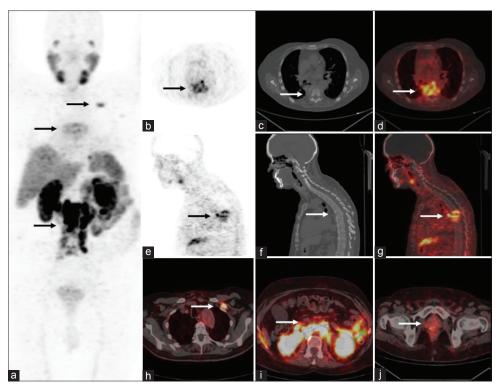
Multiple image projection (a) of whole-body Ga-68 prostate-specific membrane antigen positron-emission tomography/computed tomography scan showing multiple prostate-specific membrane antigen-avid metastatic lesions. Axial and sagittal positron-emission tomography, computed tomography, and fused positron-emission tomography/computed tomography (b-g) showing prostate-specific membrane antigen-avid destructive lesion of contiguous D6 and D7 vertebrae with associated prostate-specific membrane antigen-avid pre- and para-vertebral soft-tissue component. Fused positron-emission tomography—computed tomography images (h-j) revealing prostate-specific membrane antigen-avid left infraclavicular lymph node, abdominal lymph node, and mild inhomogeneous prostate-specific membrane antigen uptake in the primary site (prostate gland)
